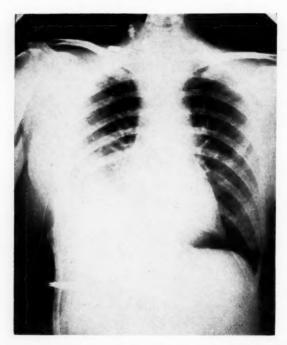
Roentgen ray film of chest May 19, 1933, showing subsidence of inflammatory process, the remaining mediastinal abscess filled with iodized oil 40 per cent and the nearly complete disappearance of right pleural effusion. The right diaphragm is definitely elevated.
